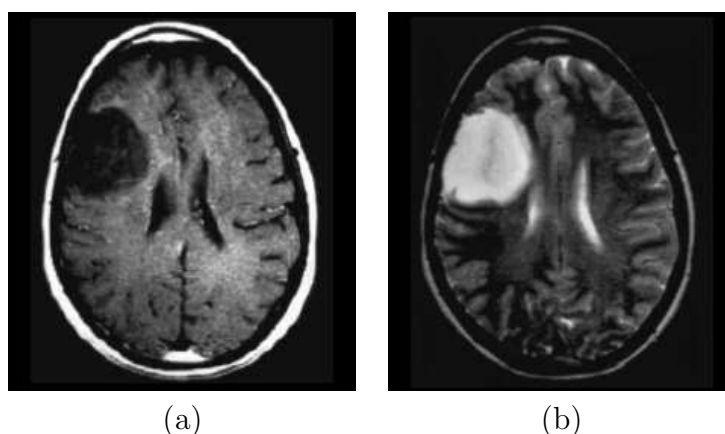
Ganglioglioma. (a) contrast enhanced axial T1-weighted MRI showing non-enhancing hypointense frontal tumor. (b) The same lesion appears hyperintense on T2-weighted MRI [Wen et al., 2001].
